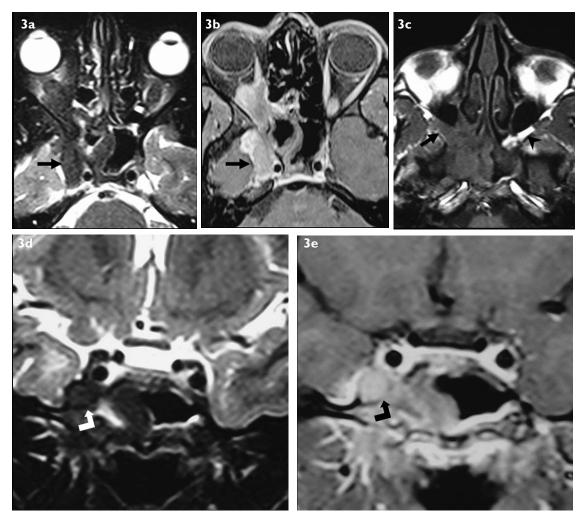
Axial (a) fat suppressed T2-W, and (b) corresponding contrast-enhanced T1-W MR images show a T2-hypointense, enhancing lesion in the right orbit and sphenoid sinus with intracranial extension along the foramen rotundum (arrow). (c) Axial T1-W MR image at a more caudal level shows replacement of fat in the right pterygopalatine fossa by isointense soft-tissue (arrow). The left side pterygopalatine fossa shows normal (fat) signal (arrowhead). (d) Coronal fat suppressed T2-W, and (e) corresponding contrast-enhanced T1-W MR images show T2-hypointense, homogeneously-enhancing soft tissue causing enlargement of the foramen rotundum (block arrow).
